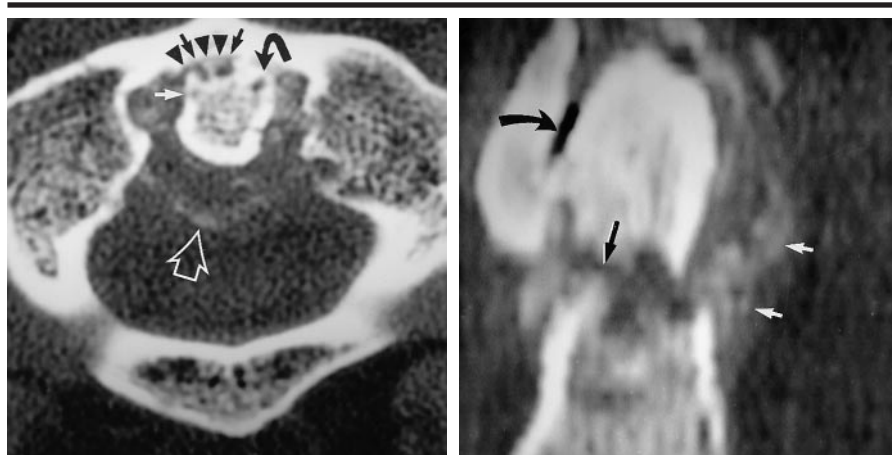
CT scans obtained in a 72-year-old man with type 2 odontoid fracture sustained after a fall down a step. (a) Transverse CT scan shows small erosions (straight solid arrows) and a subchondral cyst (curved arrow) in the odontoid process. Calcifications (open arrow) around the odontoid process are observed. The anterior median aspect of the atlantoaxial joint space (arrowheads) is narrowed. (b) CT scan reformatted in the sagittal plane shows a type 2 odontoid fracture (long straight arrow) and calcifications (short straight arrows). Gas attenuation (curved arrow) in the anterior aspect of the atlantoaxial joint also is observed.
